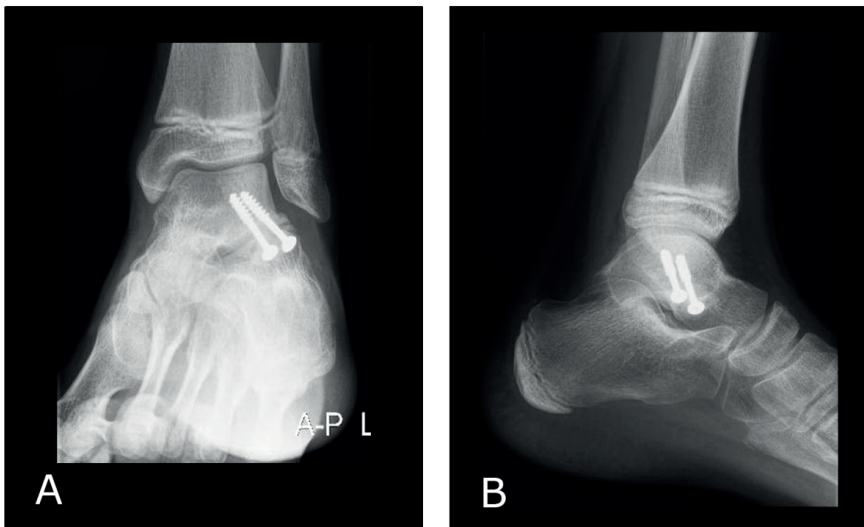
Postoperative weight bearing radiographs of the left ankle, AP (A) and lateral (B), three months after surgery, showed adequate position of the screws and early signs of consolidation.
